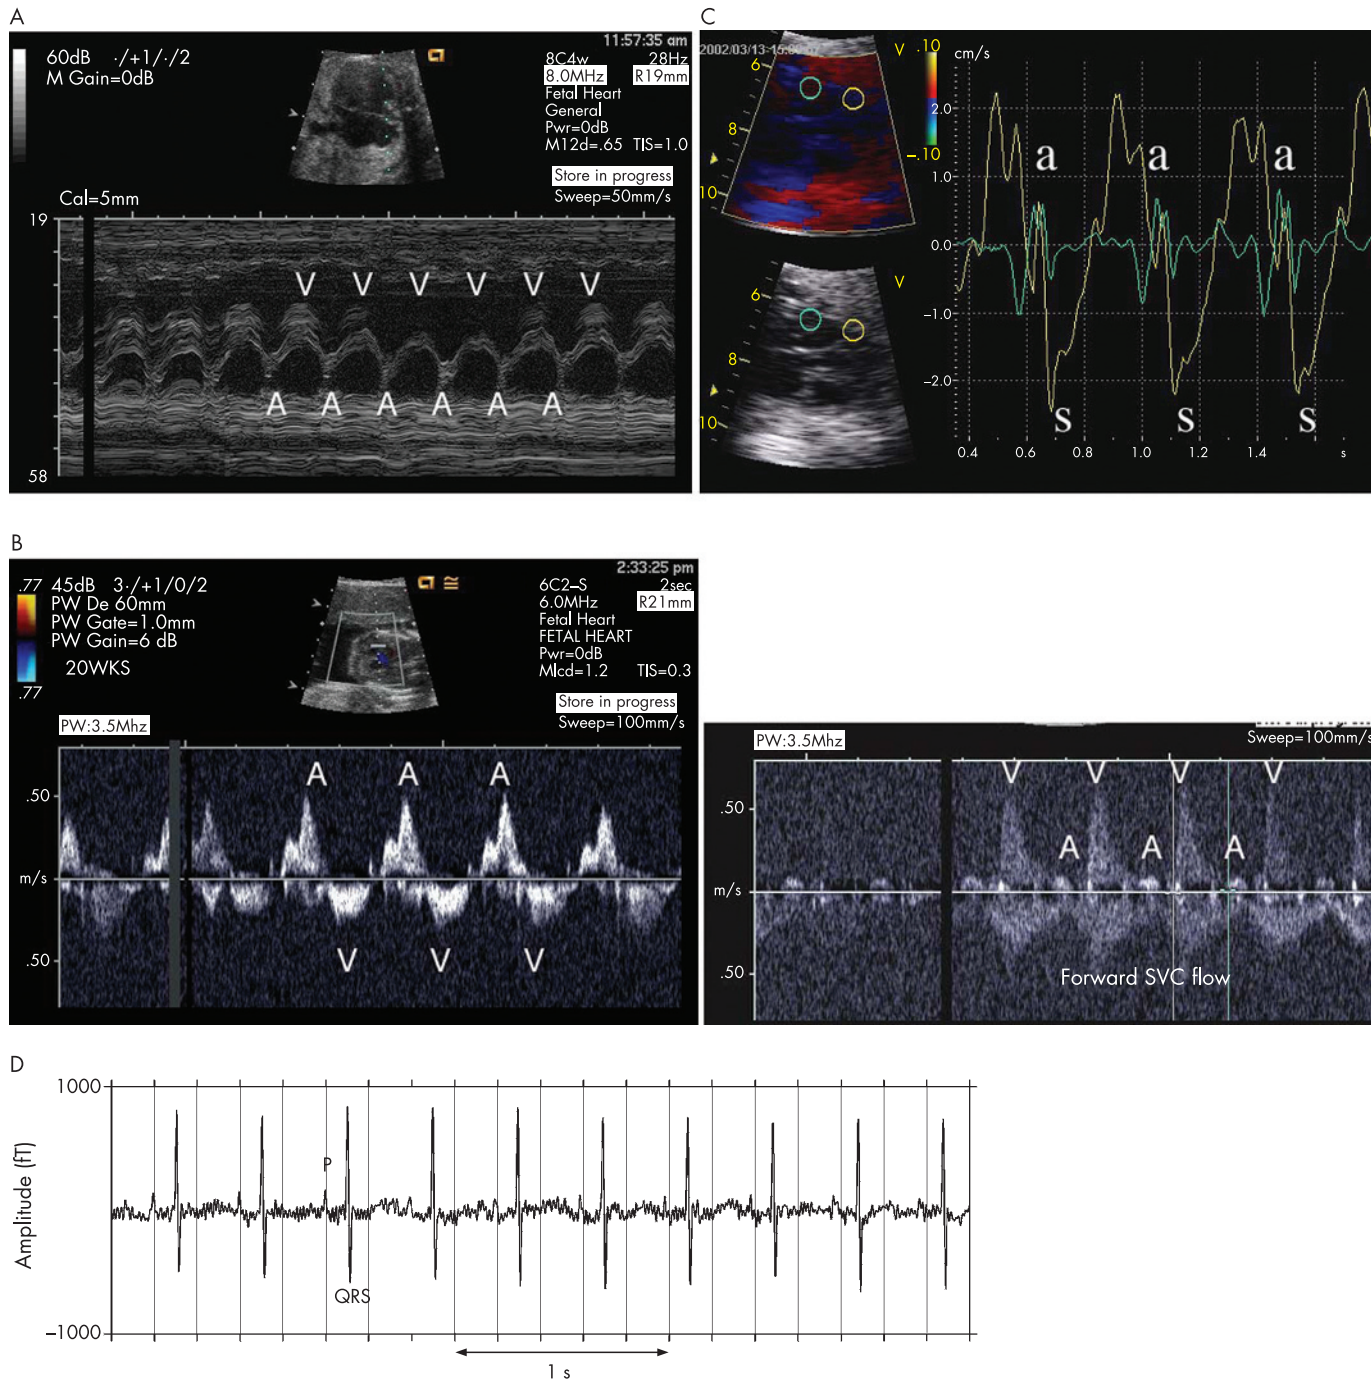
Techniques employed in the assessment of the fetal heart rate and rhythm. (A) M mode assessment in which the beam is directed through a portion of the right atrium (A) and right ventricle (V) demonstrating 1:1 mechanical atrial and ventricular relationship. (B) These Doppler spectra demonstrate Doppler assessment of fetal rhythm with simultaneous sampling of the left ventricular inflow (A: flow during atrial systole) and outflow (V: ventricular outflow) (left) and superior vena cava (SVC) and aorta (right). A: retrograde flow in SVC during atrial systole; V: forward flow in the ascending aorta during ventricular systole. (C) Left, four chamber, long axis view from which simultaneous tissue velocity data are obtained for left atrial (green) and left ventricular (yellow) wall motion. Right, the tissue velocity curves demonstrate a normal 1:1 relationship between atrial and ventricular contractions. (D) Magnetocardiogram obtained in a fetus with a normal atrial rhythm. Both P and QRS waves can be identified. (Image kindly contributed by Professor Ronald Wakai Director of the Biomagnetism Laboratory, UW-Madison.)
